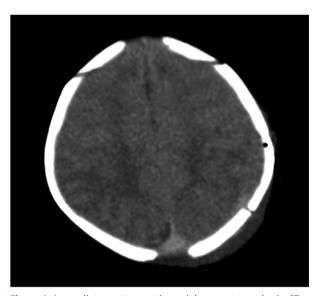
Immediate post-operative axial non-contrast brain CT shows resolution of the mass effect after evacuation of epidural hematoma. There is minimal post-operative pneumocephalus.
